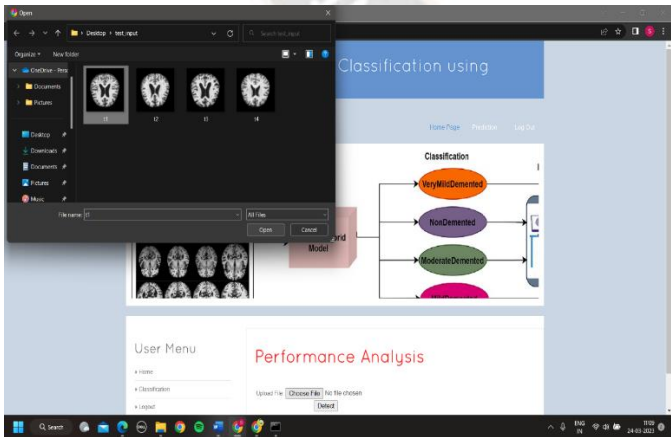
Uploading MRI scans
